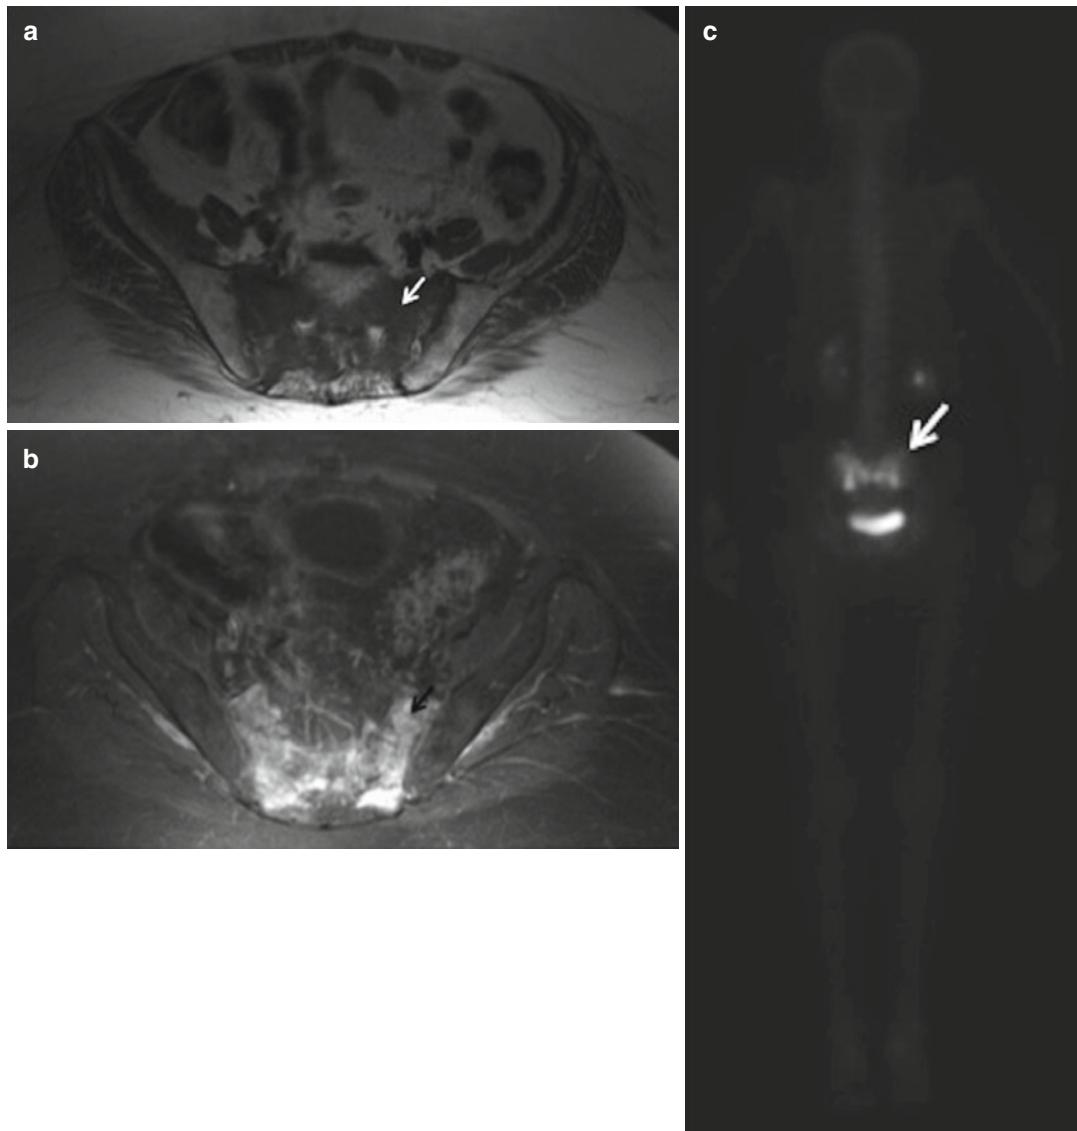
Sacral insufficiency fractures. T1-WI (a) and STIR (b) MR images show the characteristic “H pattern” of insufficiency sacral fractures with low T1 and high
